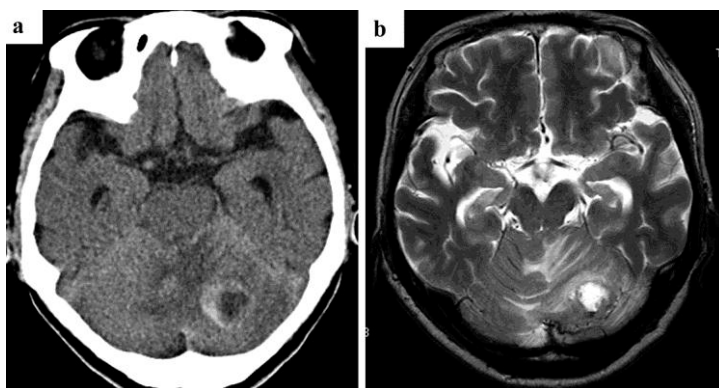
a Brain CT showing cerebral tumor with hemorrhage. b T₂-weighted MRI image of the brain.
